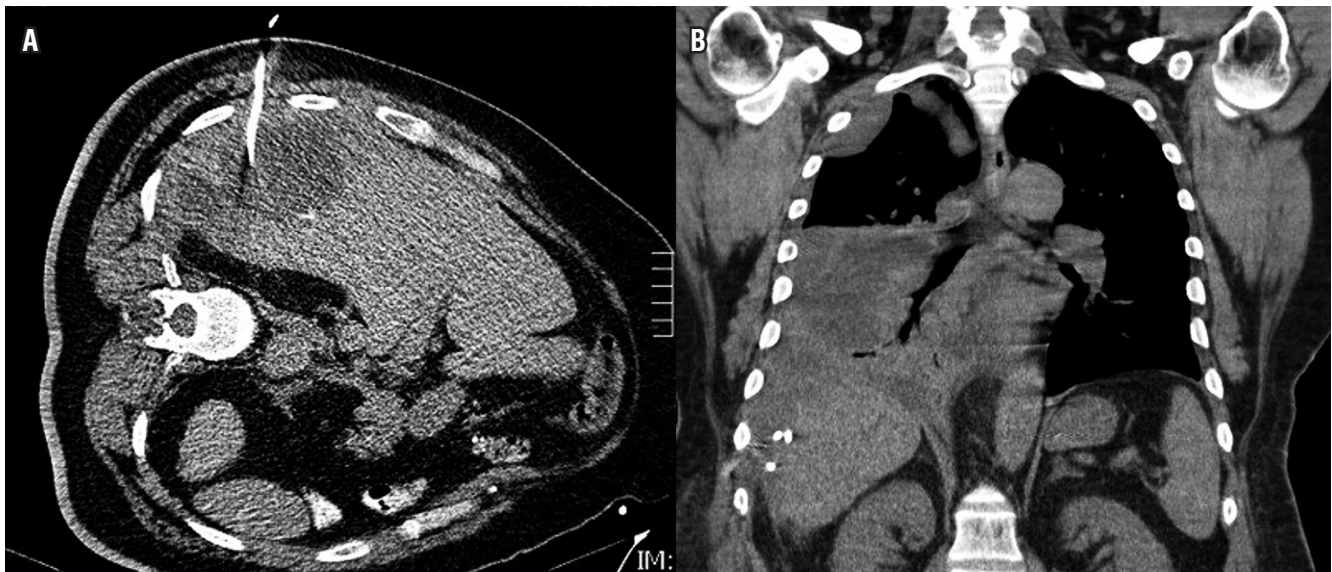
A. Failed percutaneous drainage in a patient with dropped gallstones and sup phrenic fluid collection. B. Chest CT performed 24 hours, demonstrates right pleural effusion after abdominal drainage. Notice the subcapsular location of the end of the pigtail (*).
